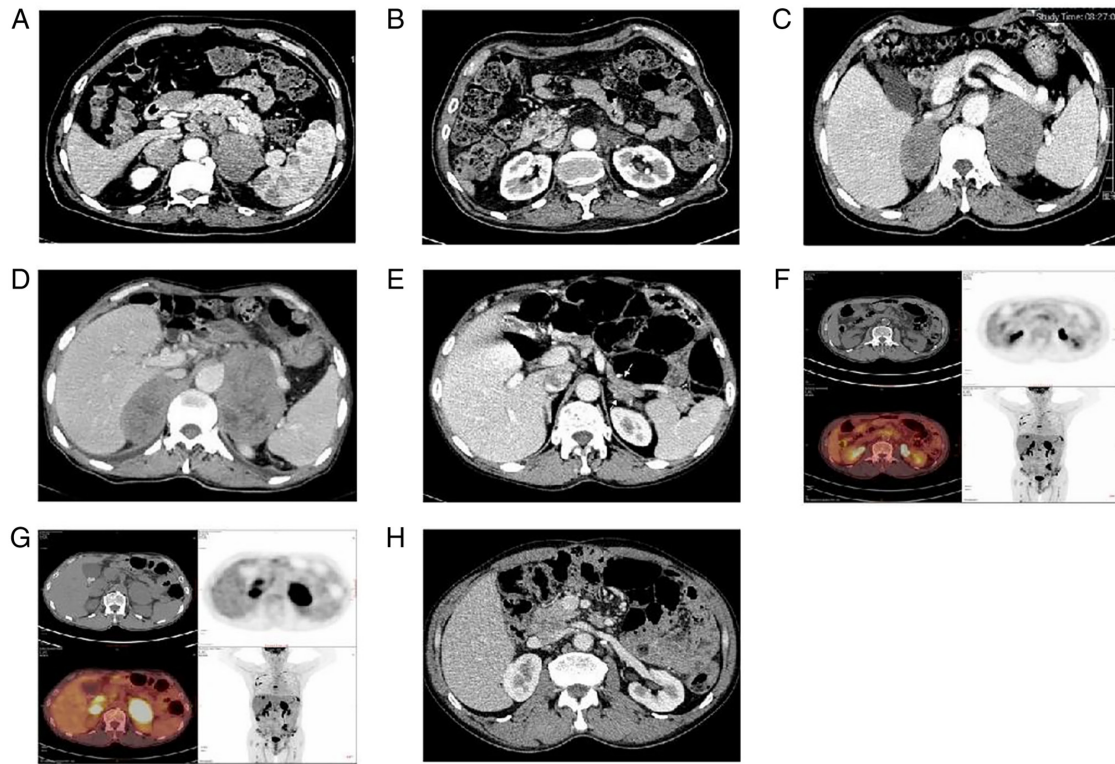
(A) Initial CT scan showing bilateral adrenal masses, with a 5.5-cm lesion in the left adrenal gland and a ~3-cm lesion in the right adrenal gland. (B) Follow-up imaging demonstrating multiple enlarged mediastinal lymph nodes and partial regression of the adrenal masses. (C) CT scan revealing progression of adrenal lesions, measuring 6.1x4.1 cm on the right and 8.4x5.4 cm on the left. (D) Subsequent imaging showing further enlargement of the bilateral adrenal masses compared with prior scans. (E) CT demonstrating bilateral adrenal masses and multiple enlarged retroperitoneal lymph nodes. (F and G) Different axial levels of the same FDG PET/CT examination. (F) Scan obtained at the renal hilar level demonstrating prominent FDG activity within the bilateral renal collecting systems, which is mainly consistent with physiological urinary excretion of FDG. No definite focal renal parenchymal hypermetabolic lesion is clearly identified on this slice. By contrast, the scan in (G) was obtained at a more cranial upper-abdominal level, where focal hypermetabolic activity is more evident in the adrenal/upper retroperitoneal region, with additional increased FDG uptake around the hepatic hilar or retroperitoneal area. Therefore, (F) mainly reflects urinary tracer excretion at the renal level, whereas (G) better demonstrates pathological FDG-avid lesions involving the adrenal and adjacent retroperitoneal regions. (H) At the renal hilar level, contrast-enhanced CT demonstrates no significant abnormalities, with incidental mild thickening of the left adrenal gland.
